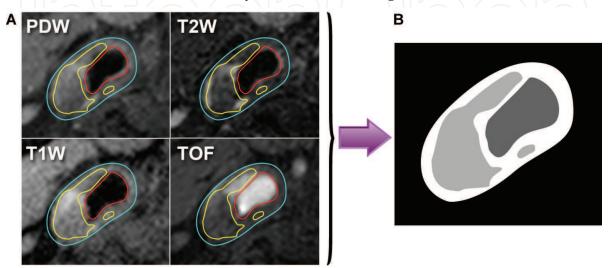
(A) Four MRI weightings were performed in order to enable segmentation into blood, vessel wall, and lipid-rich necrotic core. PDW=Proton Density Weighted image, T2W=T2 Weighted image, T1W=T1 Weighted image, TOF=Time Of Flight scan. (B) Grey-scale images were constructed from the segmented MRI images and used for constructing logical images oft he plaque morphological distribution. Visible features include blood stream (red), vessel wall (purple), and lipid-rich necrotic cores (yellow)
